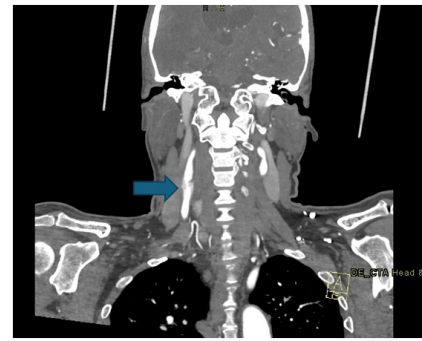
CT angiography of the neck showing a motion-degraded image with suspected luminal narrowing at the origin of the right distal common carotid artery (arrow).
